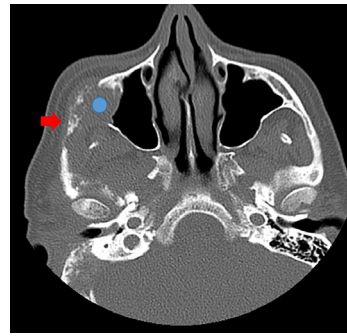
Axial pre-treatment paranasal sinus CT scan without contrast at zygomatic arch level. The red arrow shows an osteolytic metastatic lesion in the right zygomatic arch and the blue circle shows a metastatic mass lesion in the right maxillary sinus with osteolytic involvement of the posterolateral wall.
